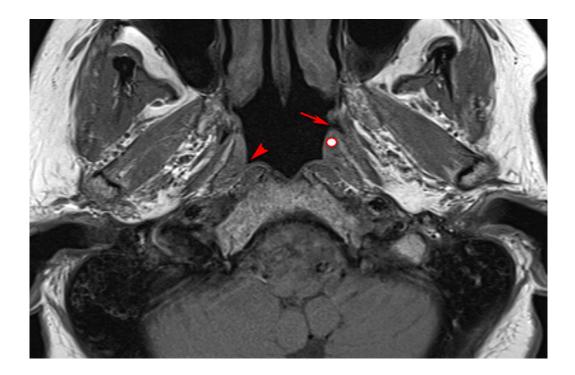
Axial non-fat-saturated T1-weighted MRI scan of the nasopharynx.
